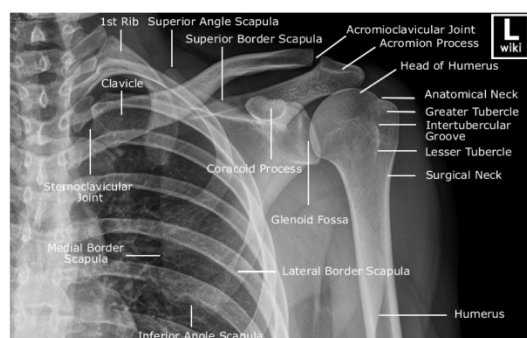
Adult shoulder radiograph (AP View). *Courtesy of wikiradiography.net*
